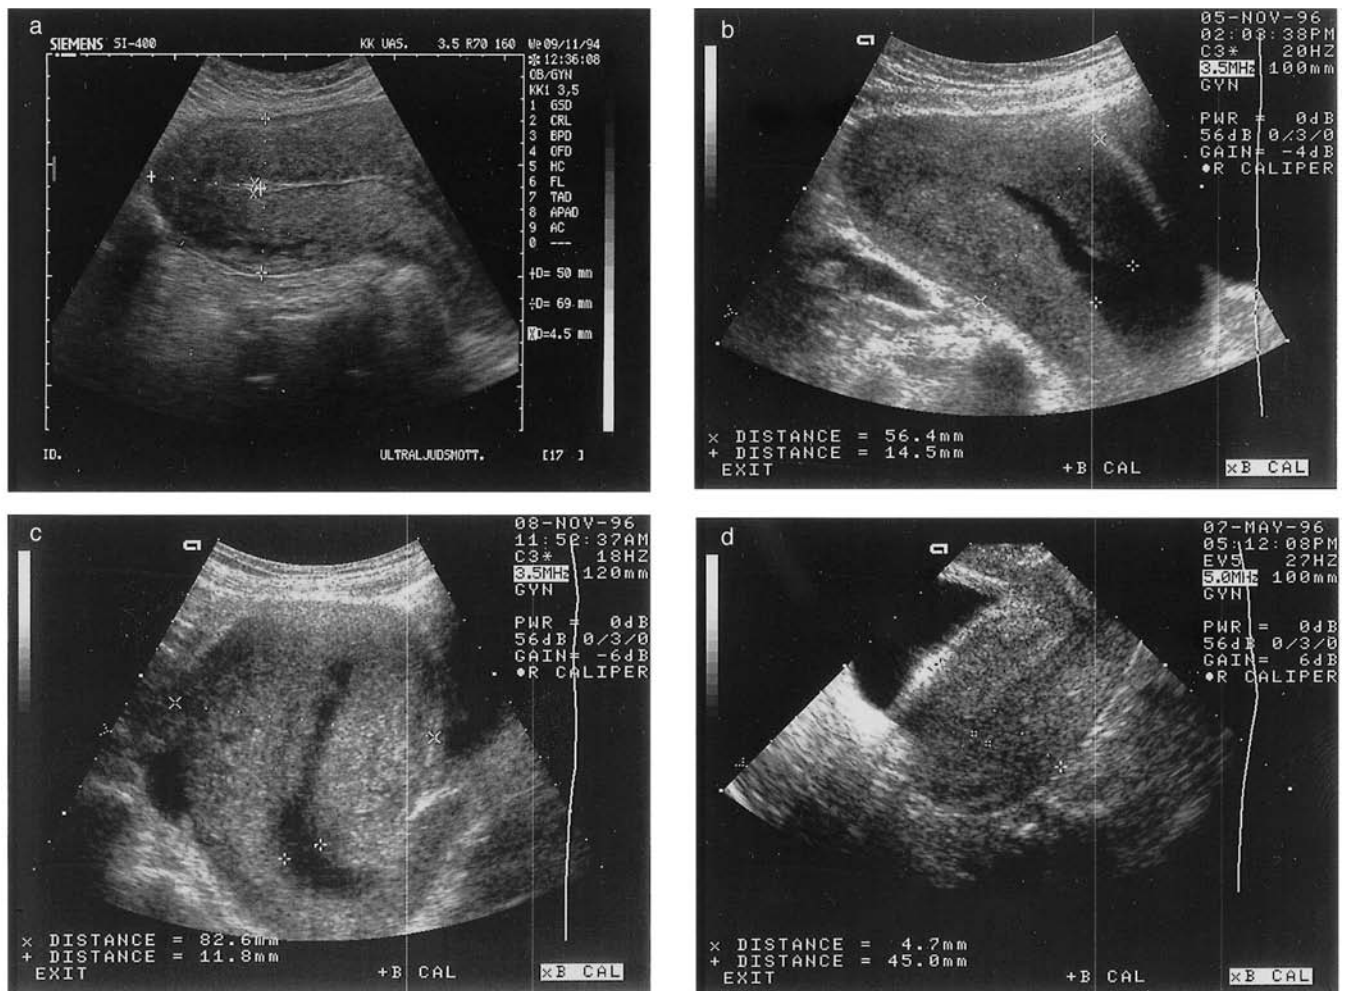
The normal ultrasound appearance of the postpartum uterus, TA approach (a, b, c) and TV approach (d). (a) On the first postpartum day the uterus has a hockey stick shape, a retroverted position and a thin endometrium. Prominent vascular channels are seen in the posterior myometrial wall. (b) One week postpartum, pure fluid is seen in the uterine cavity. (c) Two weeks' postpartum, the uterus has an oval shape, an anteverted position and a heterogenous pattern is seen in the whole uterine cavity. (d) Four weeks postpartum, the uterus is considerably diminished in size. It is empty and the uterine cavity is seen as a thin line.
